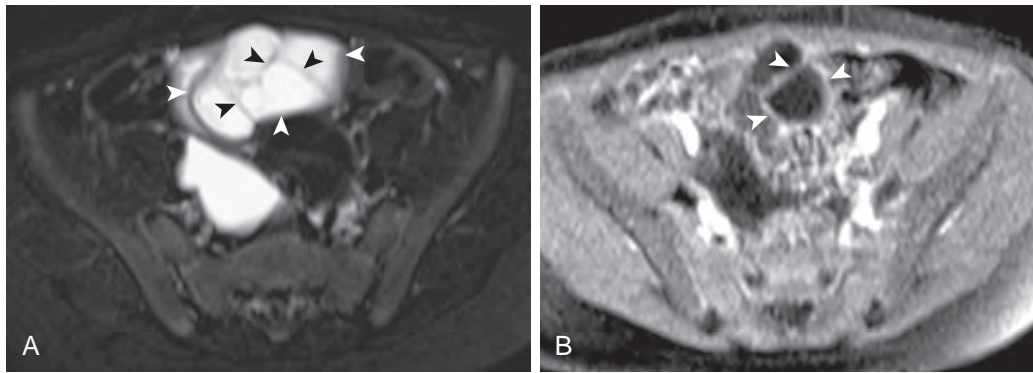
Mesenteric lymphatic malformation. A 4-year-old boy with a mesenteric lymphatic malformation. A. Axial T2-weighted fat-suppressed MR image of the pelvis shows a mesenteric mass with increased signal intensity (white arrowheads) and multiple low signal intensity thin septations (black arrowheads). B. Axial T1-weighted fat-suppressed MR image of the pelvis shows only thin peripheral and septal enhancement (arrowheads).
